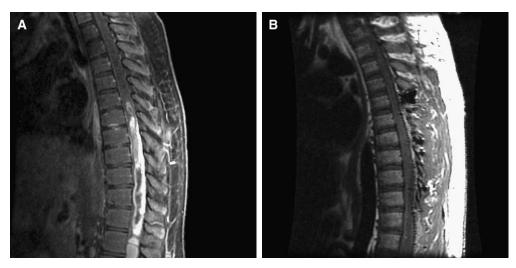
A 13-year-old male patient presented with back pain and bilateral lower extremity weakness. (A) Sagittal T1-weighted MRI scan with gadolinium revealed a partly cystic, contrast-enhancing, intramedullary tumor extending from T7 to L3. (B) Postoperative MRI scan confirms that a gross total resection was achieved. The pathologic diagnosis was consistent with an ependymoma.
